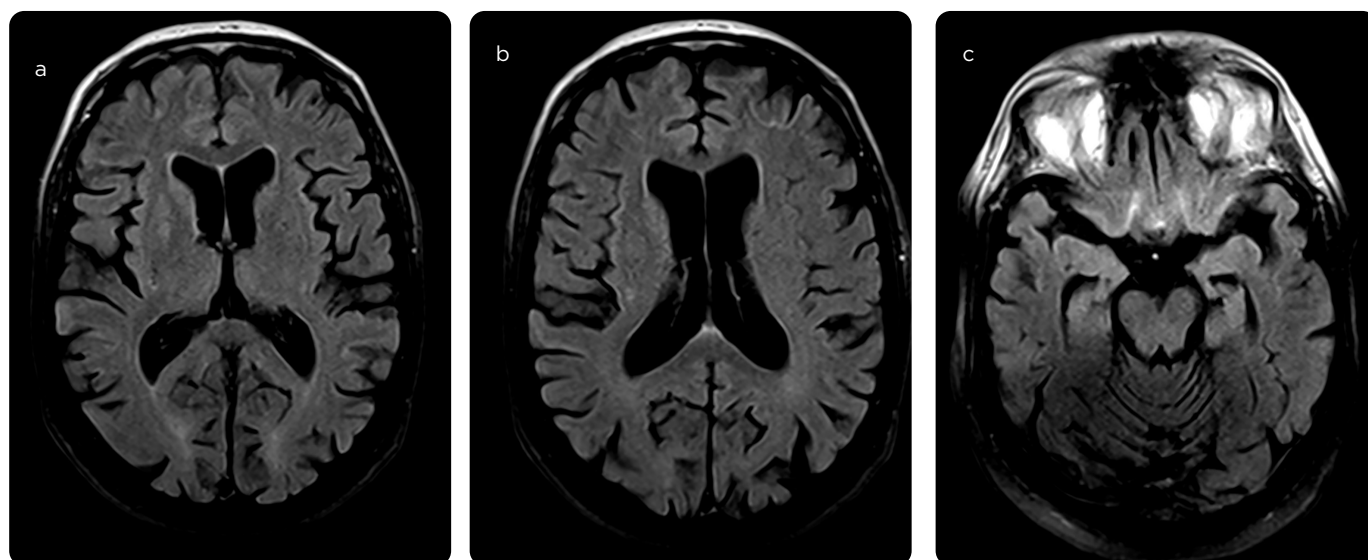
Brain MRI FLAIR sequence, axial. a, b) Areas of discrete high signal in the bilateral frontal cortex, in the cingulate gyrus cortex and c) in the bilateral temporal lobe cortex.
